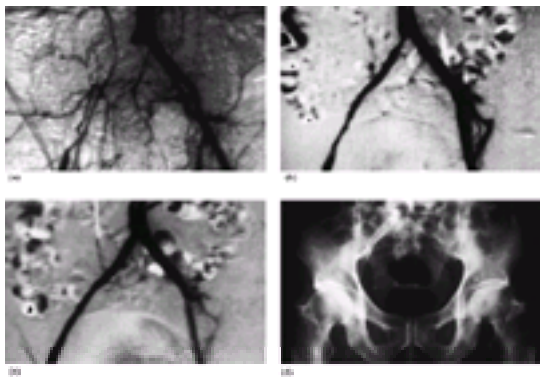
(a) Intravenous digital subtraction angiography (DSA) before angioplasty. Complete iliac communis and externa occlusion (right). (b) DSA after lysis and dilatation. (c) DSA angiogram after stent implantation. (d) Plain radiograph after stent implantation (by courtesy of Angiomed).
